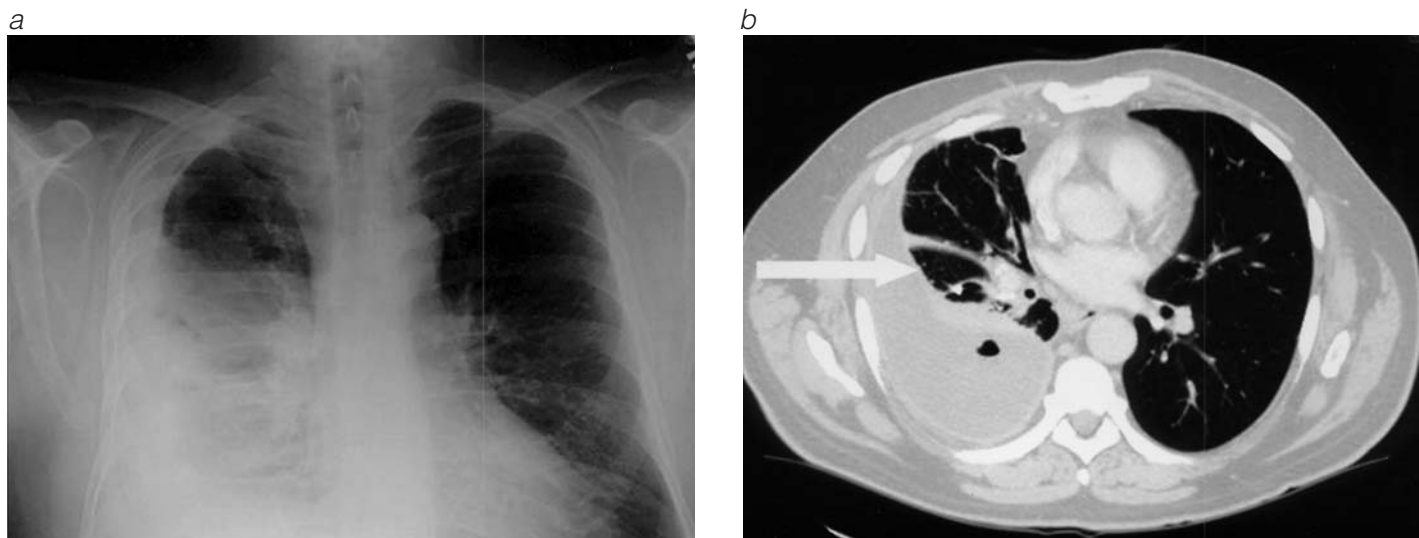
(a) Shown is a chest x-ray from a patient with a 2-month history of dyspnea and cough associated with intermittent fever and night sweats. Treatments included three courses of antibiotics and bronchodilator therapy. (b) A chest CT scan from the same patient shows a large pleural collection containing air and demonstrates pleural thickening (arrow). The findings are consistent with empyema. Thoracentesis was performed, demonstrating white, creamy purulence but failing to achieve reexpansion of the lung. Decortication was performed.
